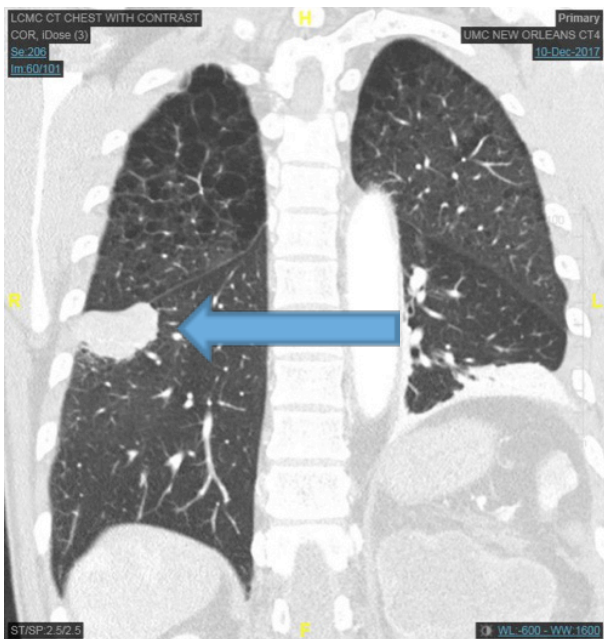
CT chest with contrast revealing mass within the right lung
